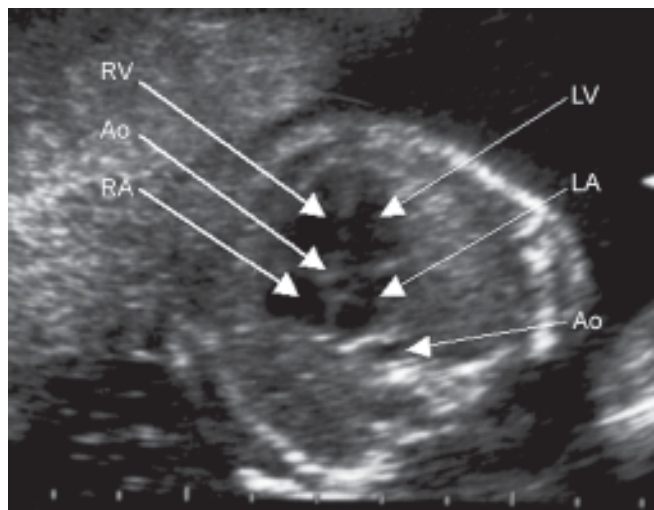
Apical five-chamber view (17th week)
